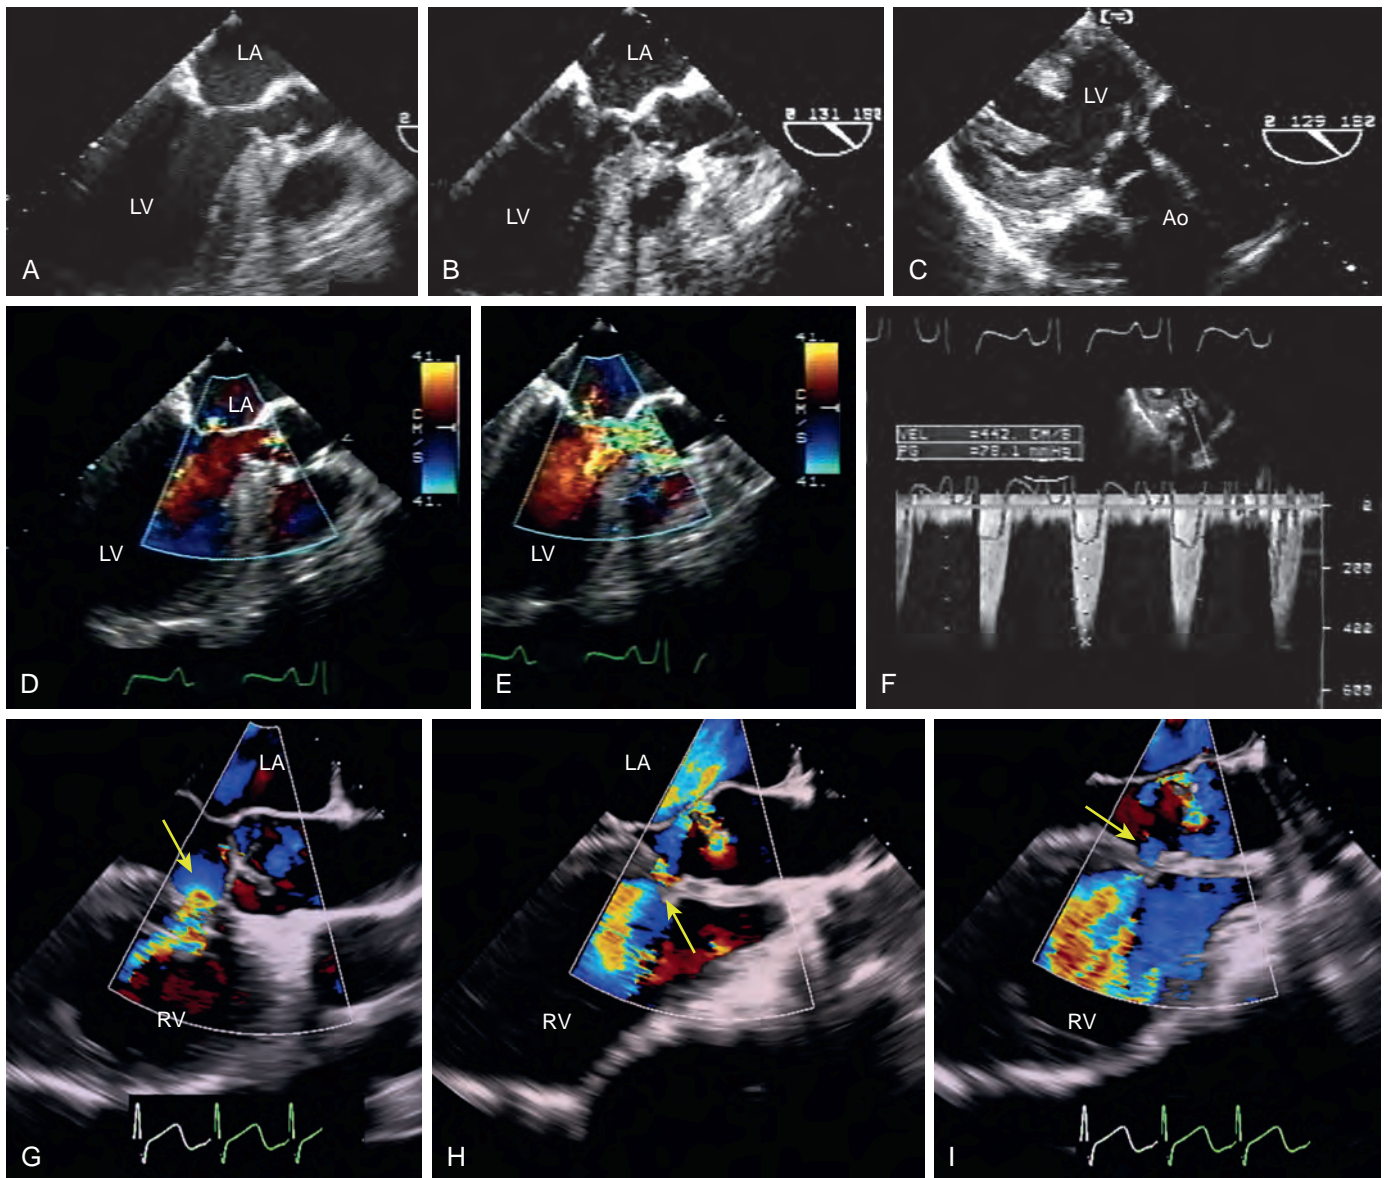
Subaortic valve membrane and ventricular septal defect (VSD). (A) Subaortic valve membrane during systole with evidence of good systolic excursion of the aortic valve (AV) leaflets. (B) Subaortic valve membrane during systole. (C) Transgastric image showing the subaortic valve membrane appearing parallel to the close AV. (D) Color Doppler image showing mild AV insufficiency. (E) Turbulent outflow consistent with a fixed outflow obstruction. Interrogation with continuous-wave Doppler across the left ventricular outflow tract records a gradient greater than 70 mm Hg. Given the normal excursion of the aortic leaflets, the elevated gradient is due to subvalvular obstruction. (G) VSD (yellow arrow). (H) and (I) VSD and coexistent (or associated) AV insufficiency. Ao, Aorta; LA, left atrium; LV, left ventricle.
